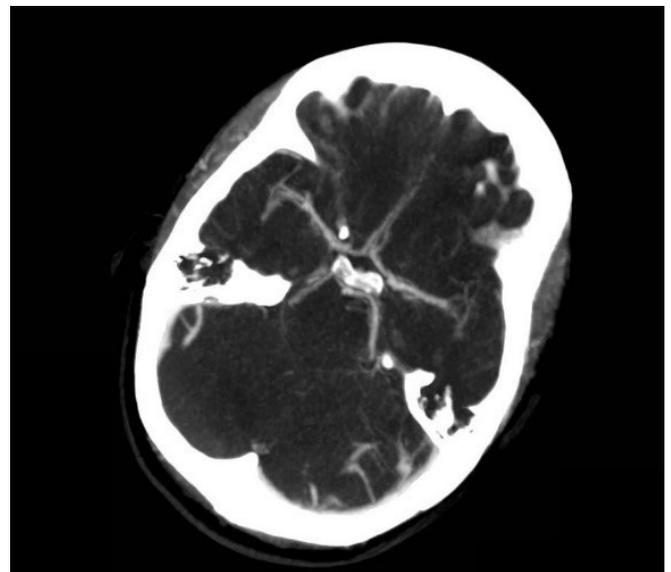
Computed tomography angiography of the intracranial arteries.
